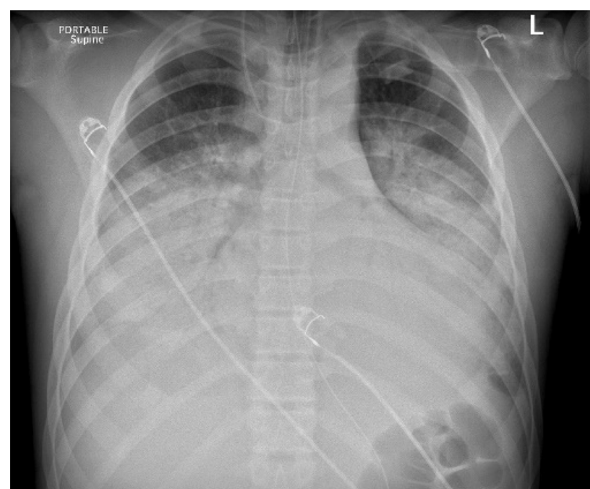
Chest radiograph on day 3, showing a diffuse hazy and coalescent airspace opacification bilaterally with a predominance in the mid and lower zones.
